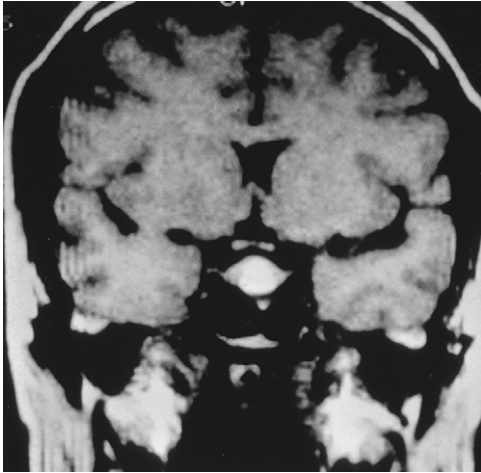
Pituitary apoplexy. T1-weighted image obtained 4 days after the acute clinical presentation shows increased signal within a pituitary mass indicating subacute hemorrhage.
